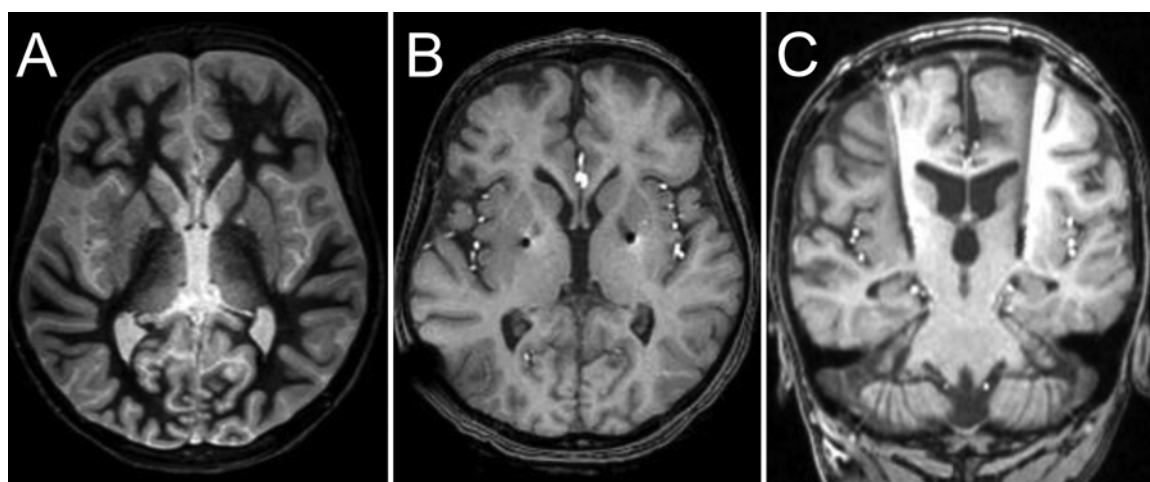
Representative MRI. A: Preoperative axial FGATIR image at the level of the GPi. B and C: Postoperative axial (B) and coronal (C) MR images demonstrating DBS lead placement in the bilateral GPi.
